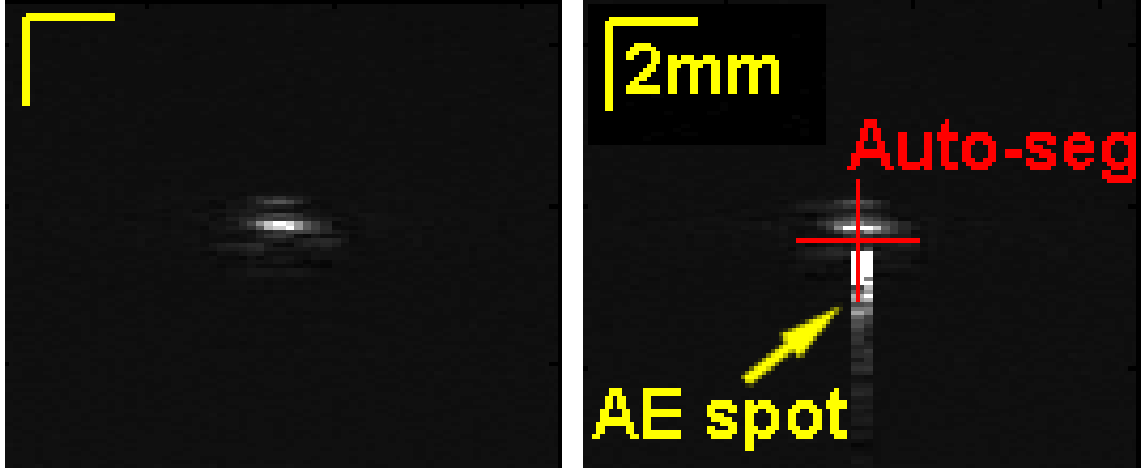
An ultrasound image demonstrating the pattern injection approach for mid-plane placement. The only change in the setup between the two ultrasound images shown is the operation of the AUSPIS feedback. The red cross also indicates the automatically segmented point.
